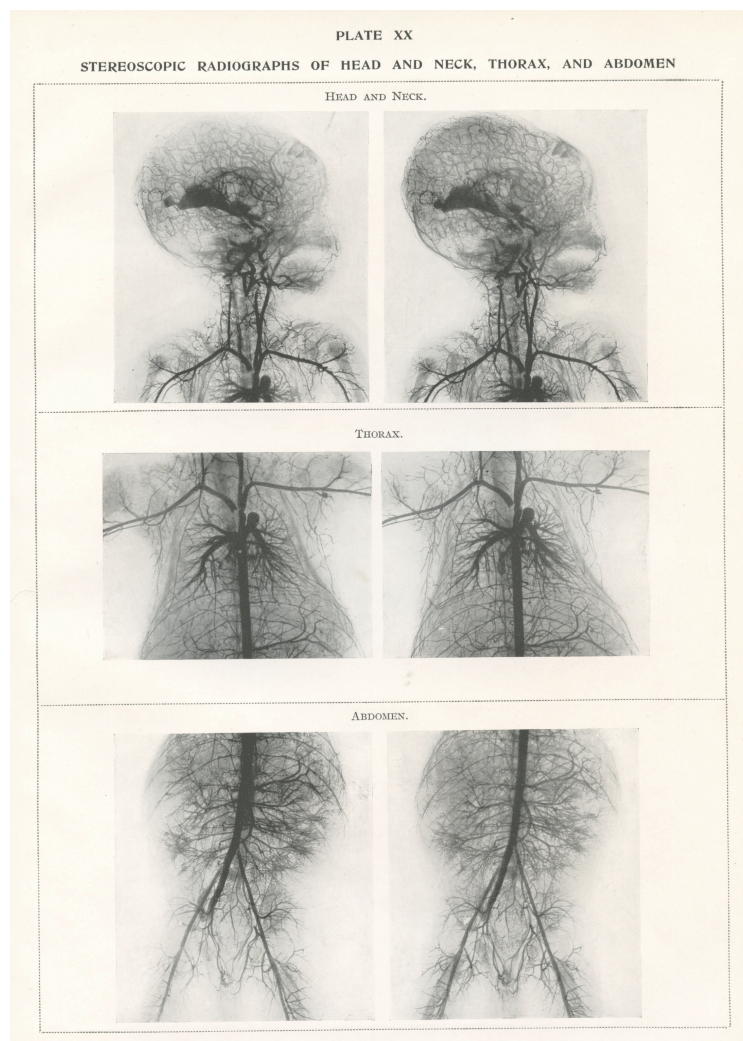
Orrin (1920) Stereoscopic Radiographs of Head and Neck, Thorax and Abdomen.
